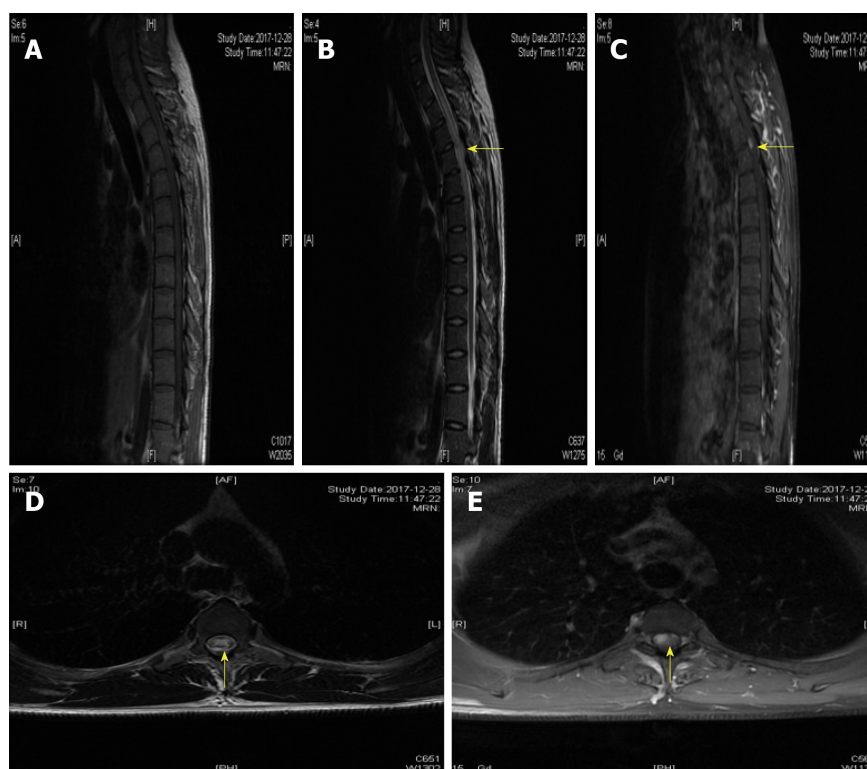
Spinal cord magnetic resonance imaging showed abnormal longitudinally extensive T2 weighted hyperintensities involving the posterior columns from C7 through T6, with "flip-flop sign" on cervical spinal magnetic resonance imaging. Focal enhancement was observed in the dorsal aspect of the thoracic cord on T1-weighted gadolinium-enhanced images at T3-T4 level.
